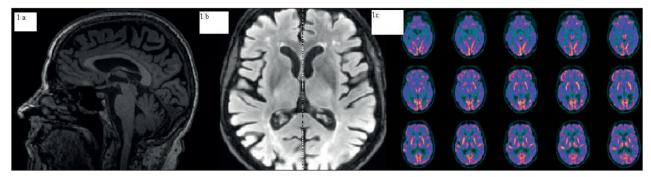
1a and 1b Brain MRI demonstrates cortical atrophy. 1c positron emission tomography (PET) revealed bilaterally reduced metabolism in the temporal poles, lateral temporal and posterior parietal areas.
